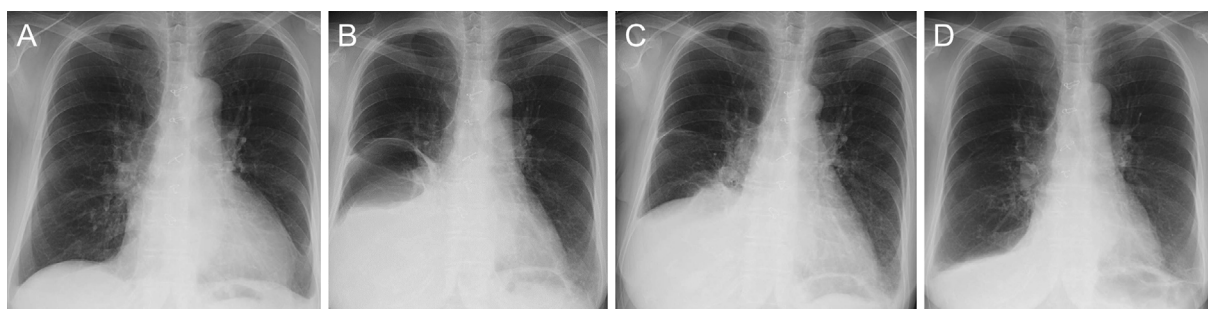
Chest radiography findings of pleural effusion. At diagnosis of A) chronic myeloid leukemia (CML) and B) chylothorax using thoracentesis and C) before and D) 16 months after the initiation of “Goreisan.”
